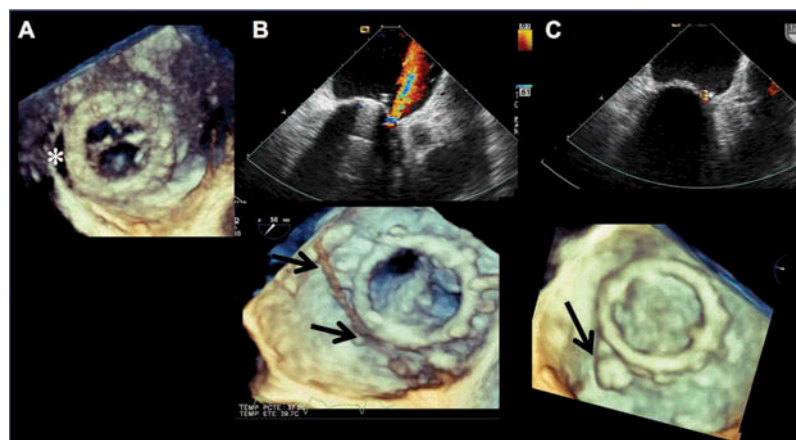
Real-time 3D echocardiographic guidance of percutaneous paravalvular leak repair procedure. 3D transesophageal guidance for percutaneous paravalvular leak repair allows for real-time assessment of the defect, wire, and equipment location. First, the defect is located (A). Next, the defect is crossed with a guidewire. Real-time 3D TEE is particularly helpful when confirming the guidewire (arrows, B) is passed through the paravalvular defect (B). After percutaneous closure is complete, location of the occluder device (black arrow, C) and absence of regurgitant flow is confirmed (C).
